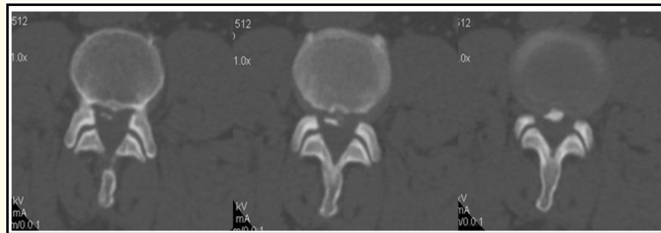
At 6 months Computed Tomography scan - union of spinous process.
